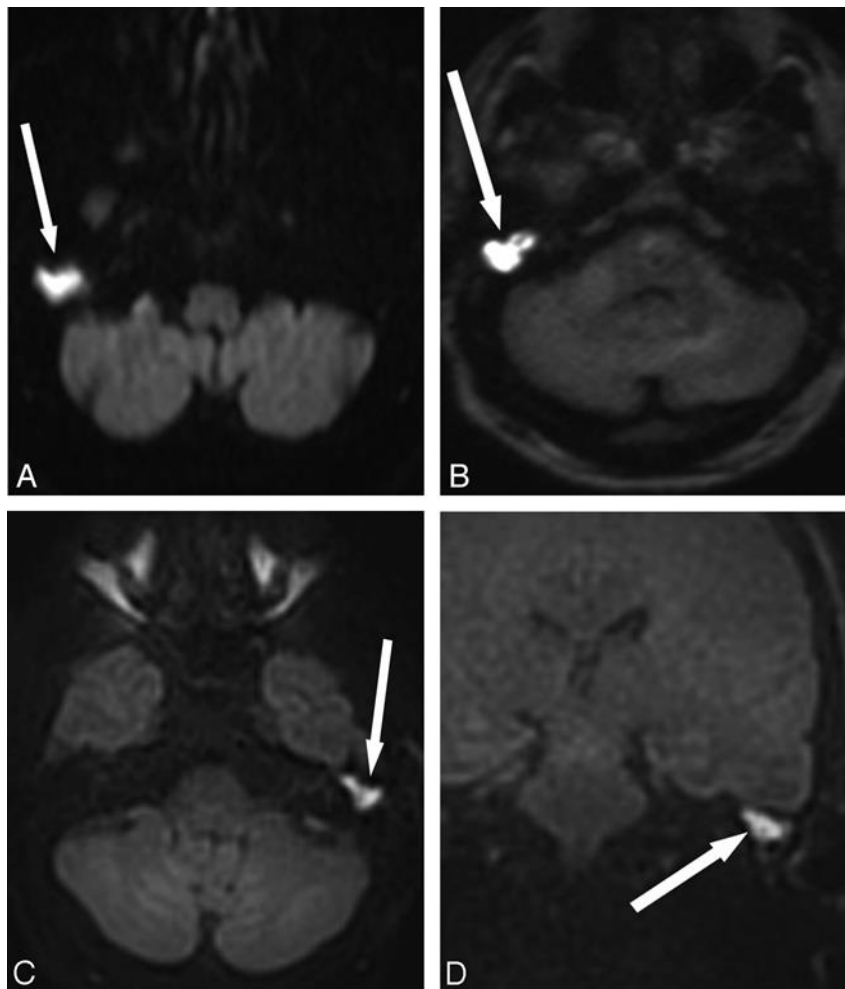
Comparison of different DWI techniques. A, EPI DWI acquired in a patient undergoing evaluation for possible demyelinating disease. Abnormal DWI signal intensity in the right temporal bone (arrow) prompted further evaluation for cholesteatoma. The abnormal DWI signal intensity is clearly visible due to the large size of the lesion, but there are artifacts from the skull base. B, SS TSE (HASTE) DWI sequences obtained in a patient with obscured visual examination due to postoperative changes. Increased diffusion signal intensity is seen in the right middle ear and mastoid defect (arrow), with cholesteatoma confirmed at surgery. C, Multishot TSE DWI (BLADE) image in a patient with otoscopic examination obscured by cartilaginous reconstruction shows increased DWI signal intensity (arrow) in the left epitympanum, with cholesteatoma confirmed at surgery. D, The multishot TSE DWI has the additional advantage of generating images in a coronal plane, which can be especially useful when erosion of the tegmen tympani and/or intracranial extension is suspected. Arrow indicates increased DWI in the left epitympanum. Fig.1B was reproduced with permission from Ear, Nose & Throat Journal (Schwartz KM, Lane JI, Neff BA, et al. Diffusion - weighted imaging for cholesteatoma evaluation.2010; 89: E14 - 19).32
